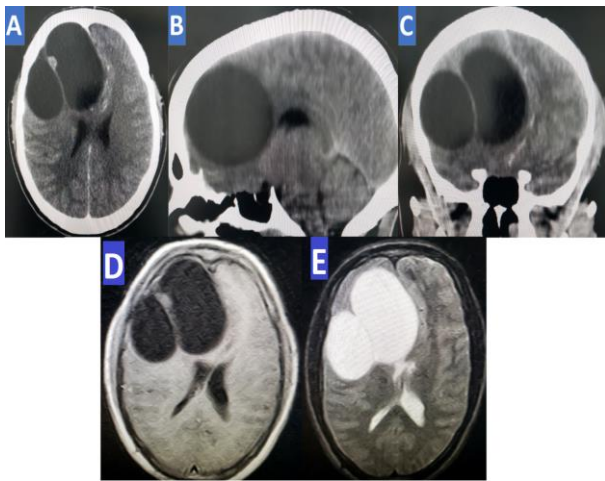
Pre-operative brain imaging: images. A: CT axiale, B: CT sagittal, C: CT coronal. D: MRI T1 WI. E: MRI T2 WI.
